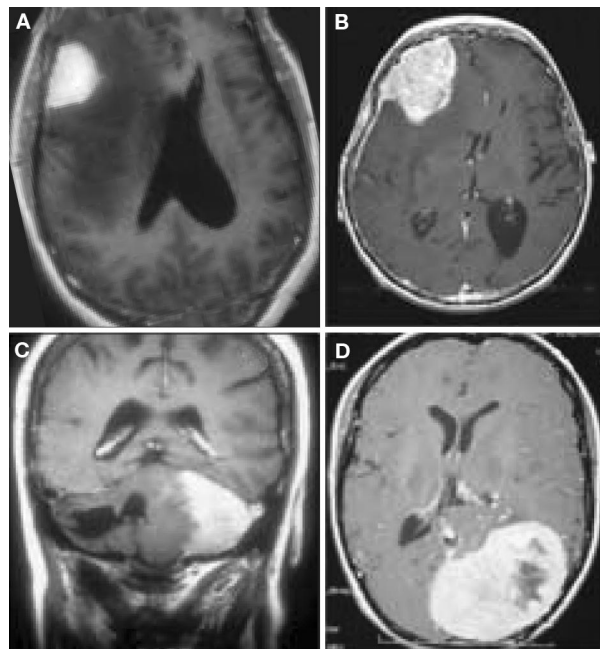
T1-weighted images of the brain with contrast showing a variety of atypical meningiomas with associated radiographic features. A, Severe peritumoral edema with mass effect and midline shift. B, mushrooming. C, wisps of contrast enhancement within the brain parenchyma consistent with brain invasion. D, necrosis.
